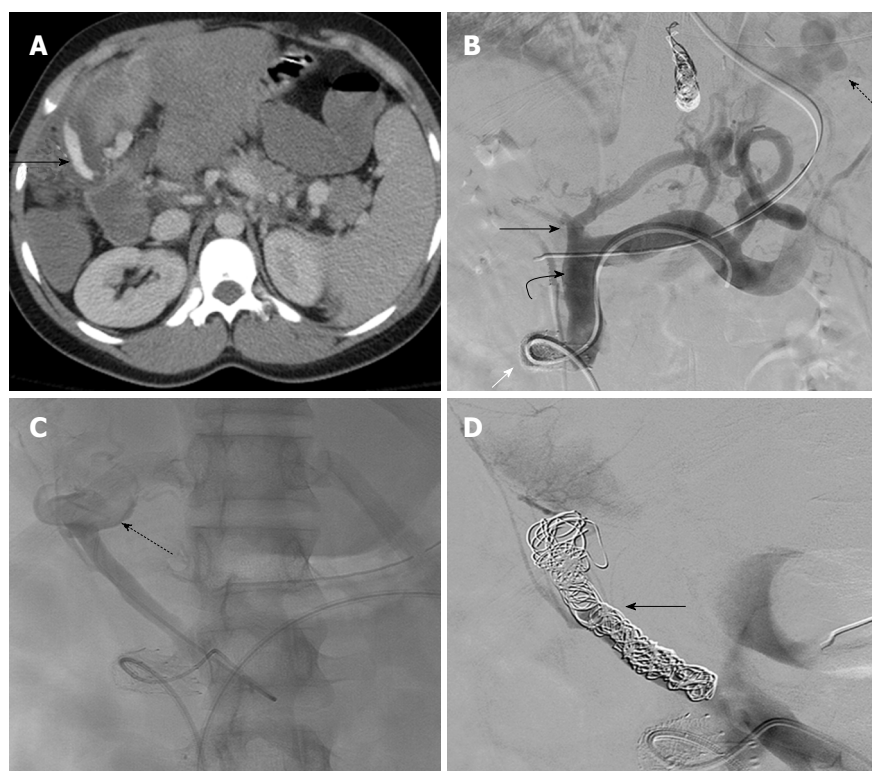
Case 2: Traumatic hemorrhage from a jejunal varix. A: Contrast enhanced computed tomography axial image shows contrast extravasation tracking along the outer wall of the hepatico-jejunostomy loop (arrow); B: Venogram performed by a trans meso-caval shunt (white arrow) approach shows large gastric fundal varices (dotted arrow), dilated superior mesenteric vein (curved arrow). The main portal vein is obliterated (black arrow); C: Selective venogram of the hepaticojejunostomy loop branch of the superior mesenteric vein shows dilatation of this branch with active extravasation of the contrast from the hepaticojejunostomy loop (dotted arrow); D: Multiple coils were used to occlude the branch (arrow).
